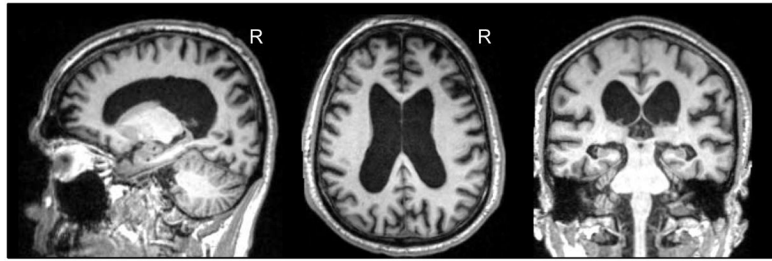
T1-weighted 3T MRI of Case 4, showing mild global atrophy with slight posterior predominance and bilateral hippocampal atrophy.
